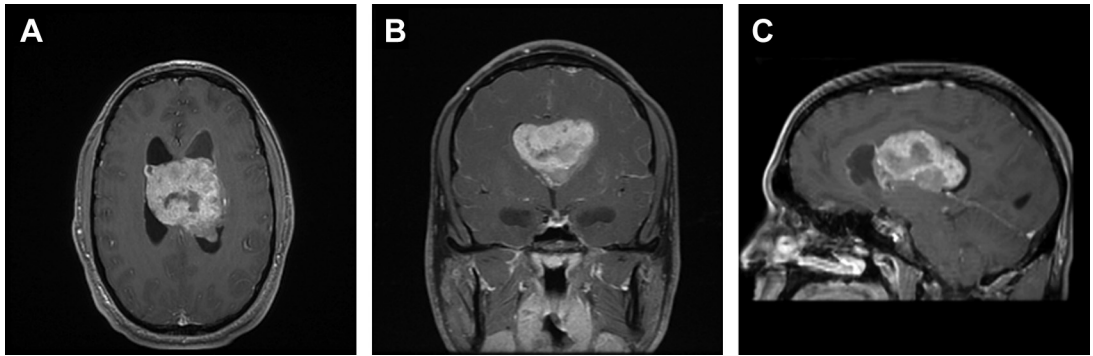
Select axial (A), coronal (B), and sagittal (C) contrast-enhanced MRI images demonstrating the typical appearance of a central neurocytoma showing a well-circumscribed, heterogeneously enhancing, “bubbly” appearing intraventricular lesion. Note the associated hydrocephalus with very enlarged temporal horns on the coronal image.
